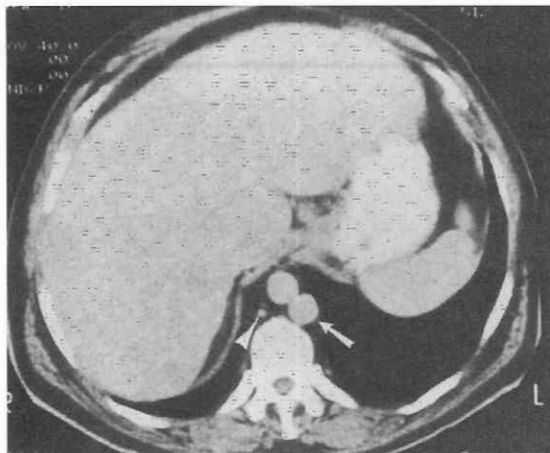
Hemiazygos continuation of a left inferior vena cava. Nondynamically enhanced CT scan shows an enlarged hemiazygos vein (arrow) but a normal-sized azygos vein (arrow-head). The subhepatic, suprarenal portion of the inferior vena cava is absent. The liver is enlarged and heterogeneous because of the presence of infiltrative metastatic disease.
